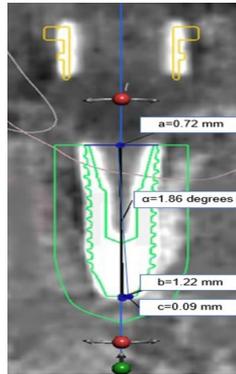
Superimposition of preoperative and post-operative CBCTs using the surgical sleeve as a reference and measurement of operator error.
